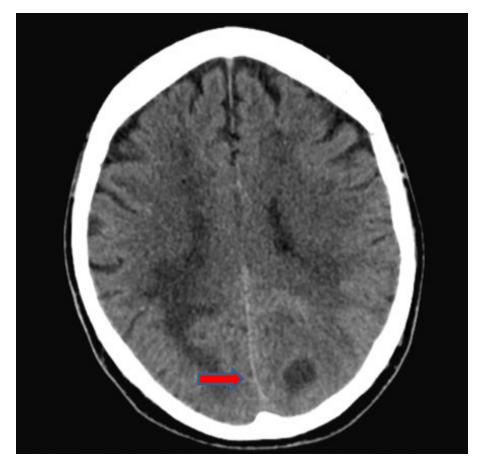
A focal, round area of hypoattenuation in the left parieto-occipital region measuring 1.9 x 1.6 cm in size on CT of the head without contrast.
